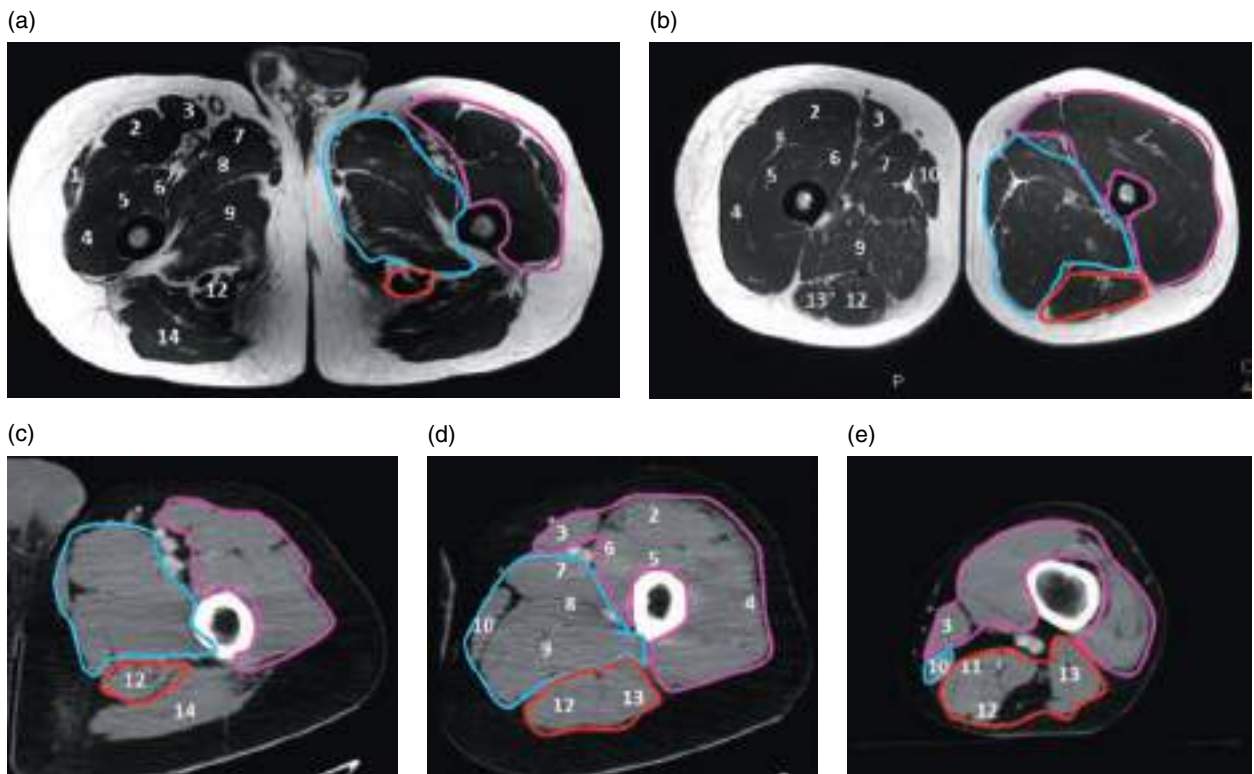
Compartments of the thigh in MRI (a, b) and CT images (c–e). The anterior compartment (pink) contains the tensor fasciae latae (1), rectus femoris (2), sartorius (3), vastus lateralis (4), medialis (5), and intermedius (6) muscles. The medial compartment (blue) contains the adductor longus (7), brevis (8), magnum (9), and gracilis (10) muscles. The posterior compartment (red) contains the semimembranosus (11), semitendinosus (12), and biceps (13) muscles. 14, gluteus maximus muscle.
